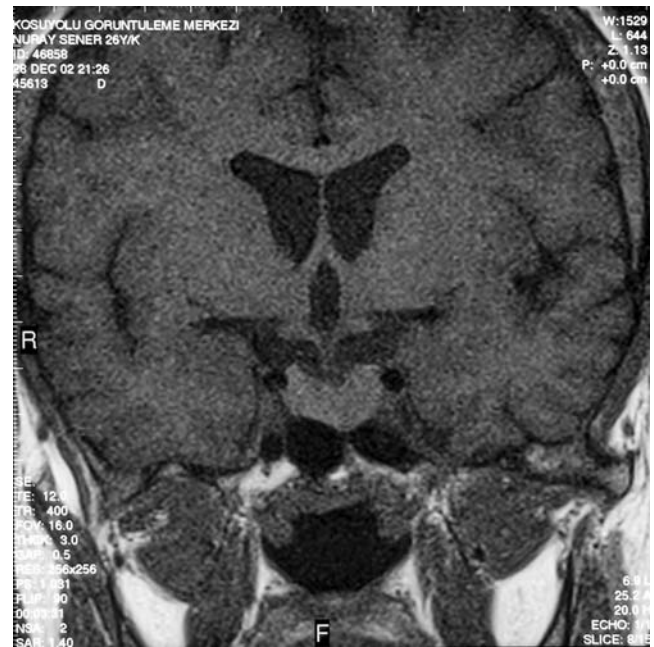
Sellar magnetic resonance imaging of the patient, showing no clear-cut evidence of pituitary adenoma responsible for acromegaly
